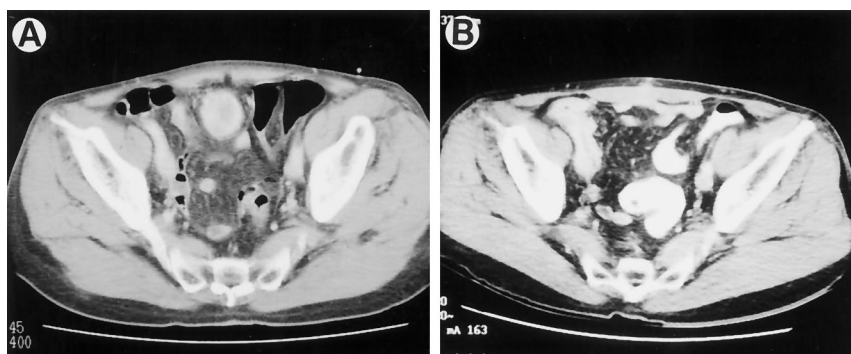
Abdominal CT. A, urachal tumor. B, at 7-month followup no tumor recurrence is evident
